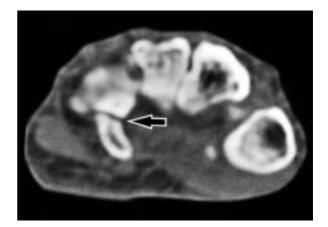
Fracture of the hook of hamate (CT image)
